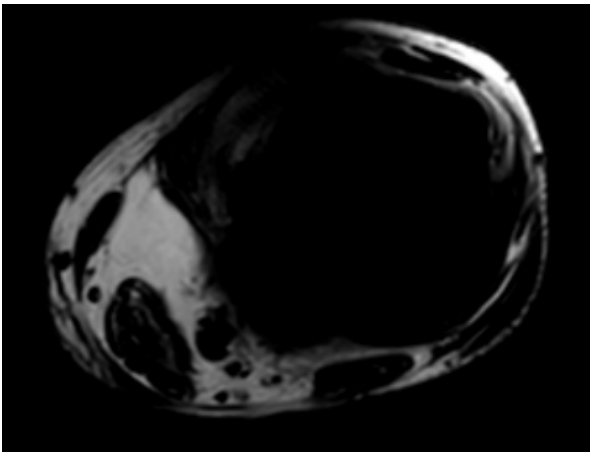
MRI-T1W axial image
